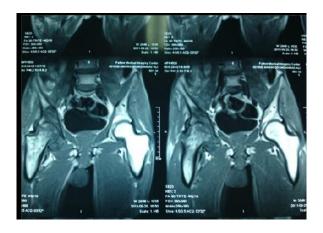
Pelvic MRI on admission showing irregularities and flattening of the femoral head, loss of joint pace, and cortical eruption in the femoral head and neck in the right side
